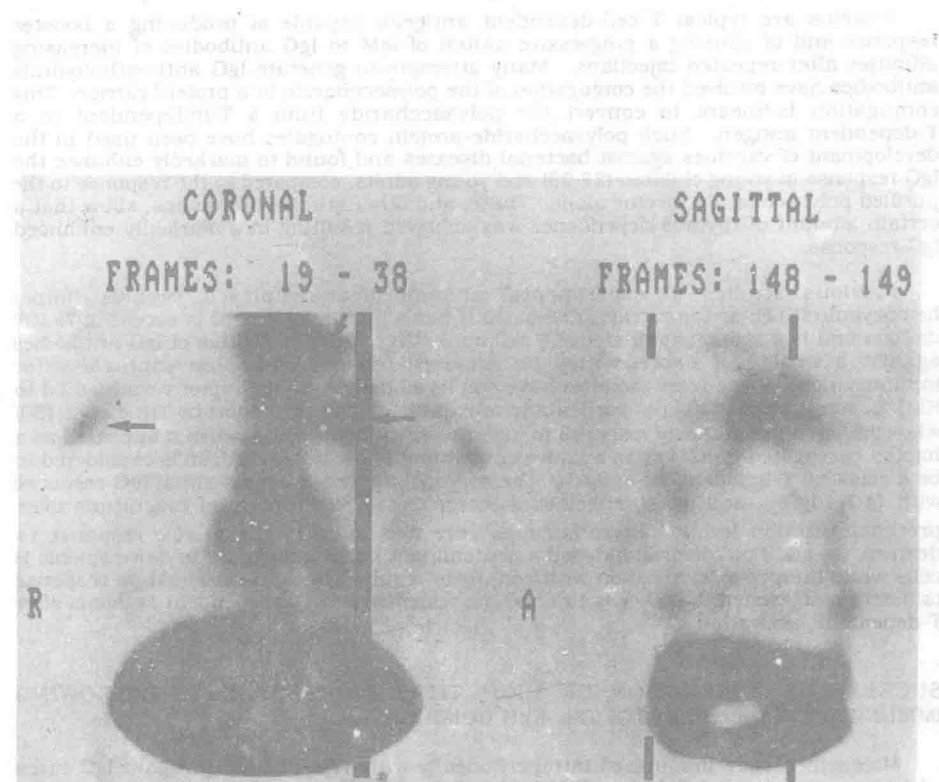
$^{111}\text{In.170H.82}$ SPECT: Uptake in metastases in nodes and lung.
